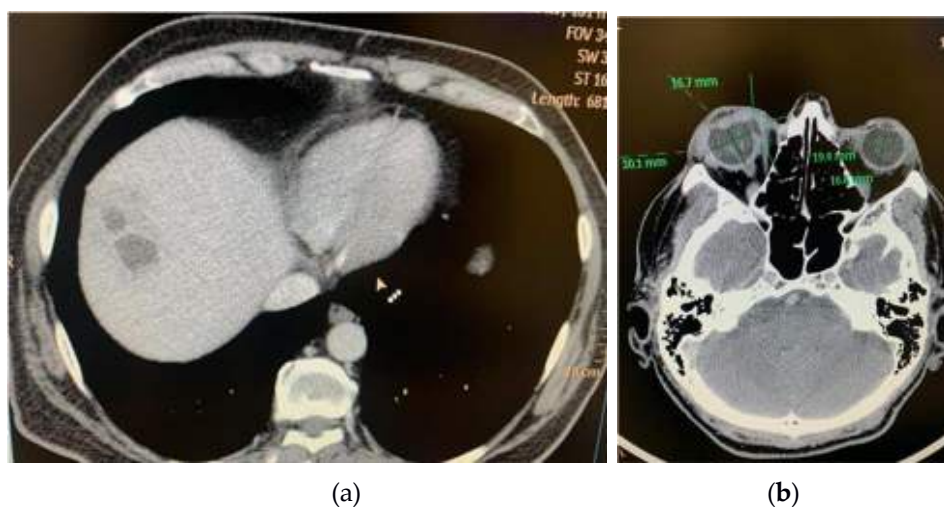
(a) CT exam: multiloculated hepatic liver abscess, right lobe, segment VIII, 50/32/57 mm; (b) CT Exam: Right eye endophthalmitis, eyeball with irregular contour, with a hypodense area in the internal side (at the area of the insertion of the medial rectus muscle), with possible communication between posterior chamber and periorbital space (perforation) (archive of the Ophthalmology Department, Emergency University Hospital Bucharest).
